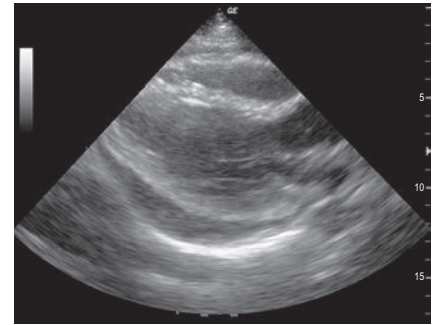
Parasternal long-axis view of the heart demonstrating a moderately-sized pericardial effusion.
